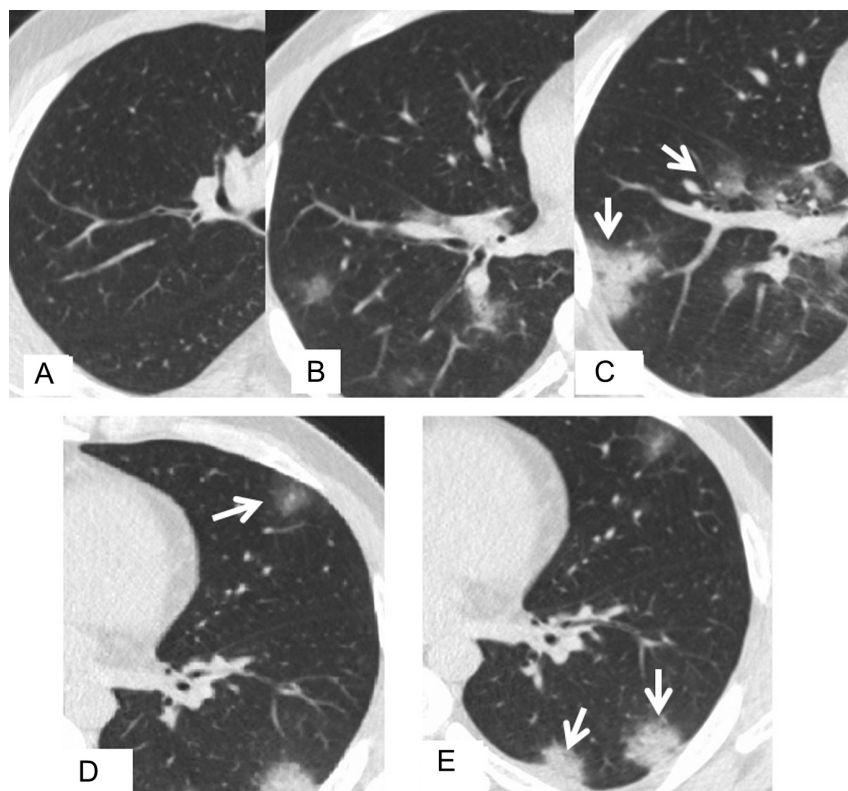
CT severity scoring. (A and B) No infiltration is present at right upper and middle lobe, (C) 26-50% of the right lower lobe is infiltrated, (D) 5-25% of the left upper lobe is infiltrated, (E) 26-50% of the left lower lobe is infiltrated. The total CT severity score of the patient is 8.
